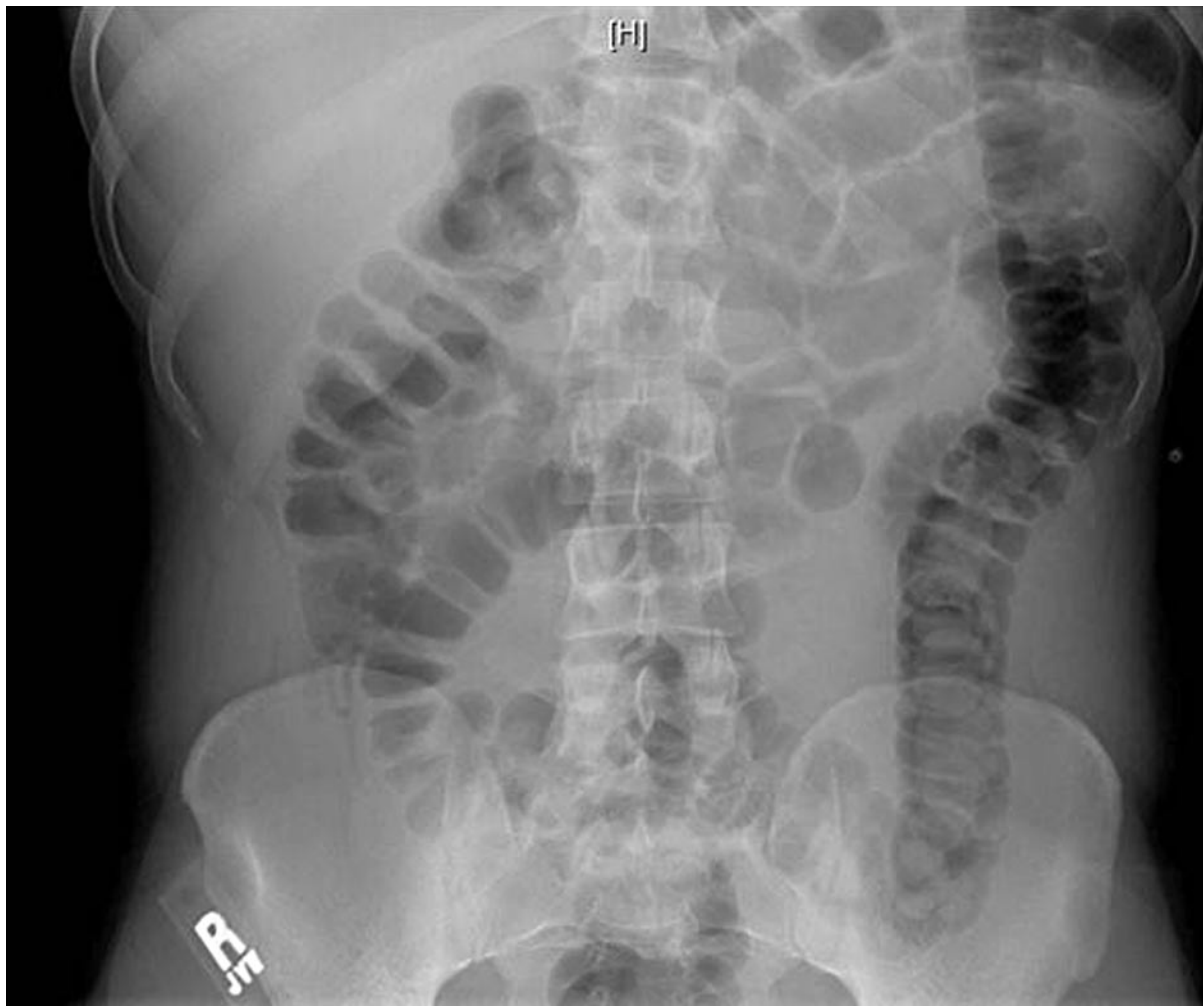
Abdominal X-ray showing dilated loops of bowel with intra-appendiceal air.
